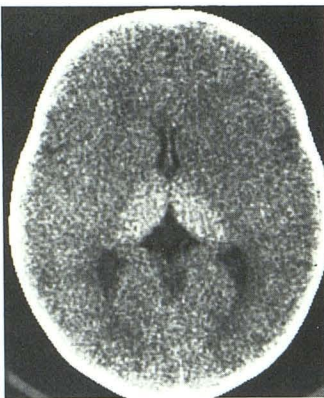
Unenhanced CT scan shows poor definition of differentiation between gray matter and white matter and thalamic hyperdensity. No increase in thalamic attenuation occurred after administration of IV contrast material.
